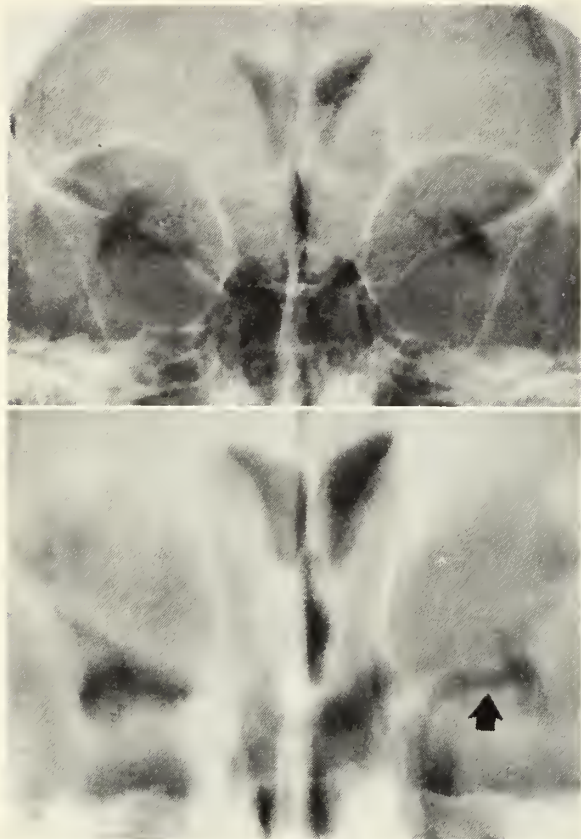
Anteroposterior projection of a pneumoencephalographic study, after forward somersault with bilateral filling of the temporal horns. A, top) Conventional radiograph. B, bottom) Tomographic section through the mid portion of the temporal horns, revealing a pathological distortion of the left horn (arrow) which was not evident on the conventional film.
